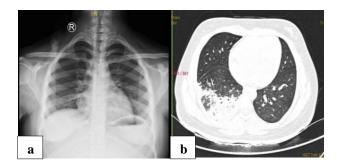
(a) X-ray chest postero-anterior view, and (b) HRCT thorax done one week later.
